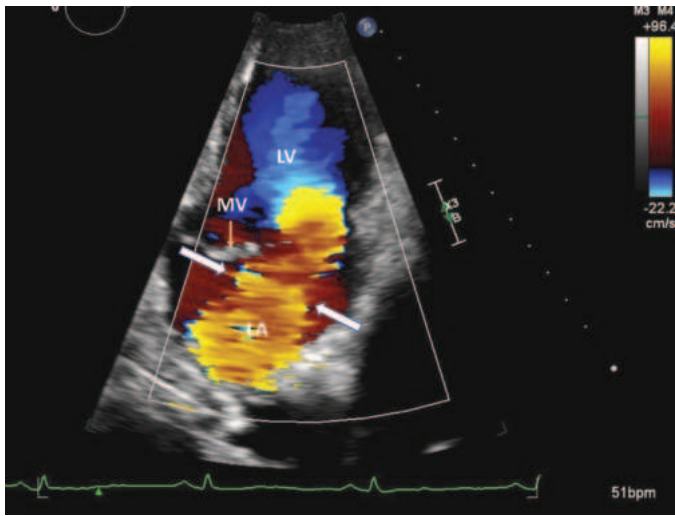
Mitral regurgitation. Apical two-chamber transthoracic color flow Doppler echocardiographic display of a broad systolic jet of severe mitral regurgitation (yellow stream between the two white arrows) from the left ventricle directed posteriorly into the left atrium. LA, left atrium; LV, left ventricle; MV, anterior leaflet of the mitral valve.
